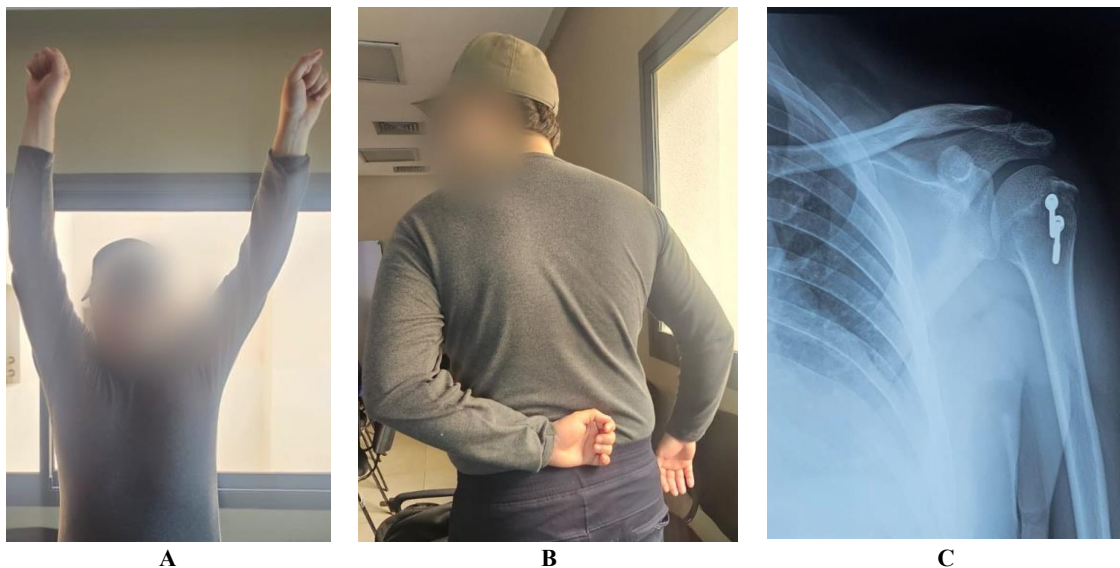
Three-month follow-up. (A) Active abduction to 160°. (B) Internal rotation to 70°. The faces were blurred to preserve anonymity. (C) Radiograph showing complete union of the greater tuberosity fracture with the implants in place
